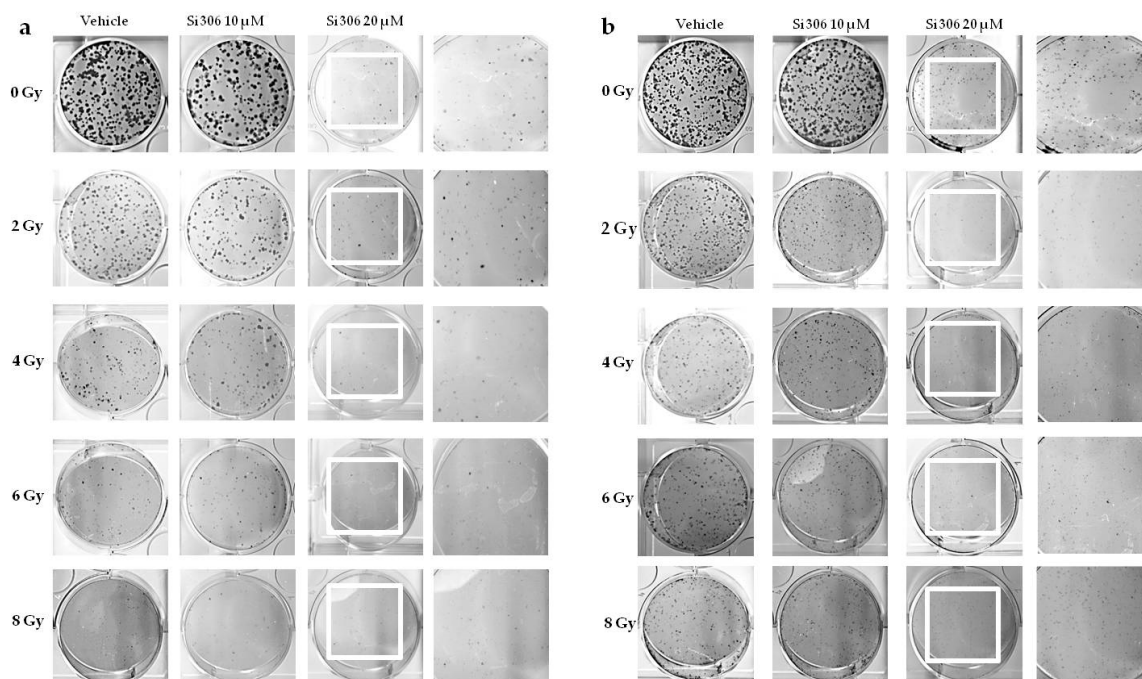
U251 clones after X-ray irradiation combined with Si306 in normoxia (21% oxygen) (a) and hypoxia (1% oxygen) (b).
